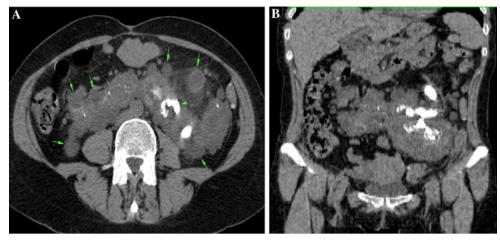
a Unenhanced CT scan in the oblique axial view, showing multiple cysts (*arrows*) involving the horseshoe kidney, with associated multiple renal stones (*arrowhead*). b Unenhanced CT
